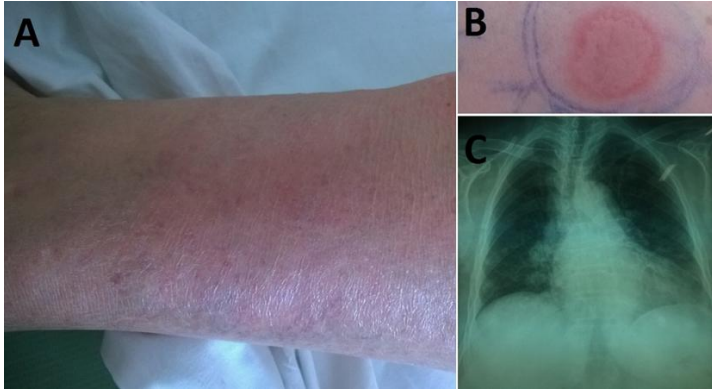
A) Erythema nodosum on the patient's left shin; B) Positive Mantoux test; C) Chest X-Ray demonstrating hilar lymphadenopathy, mainly at the right side
